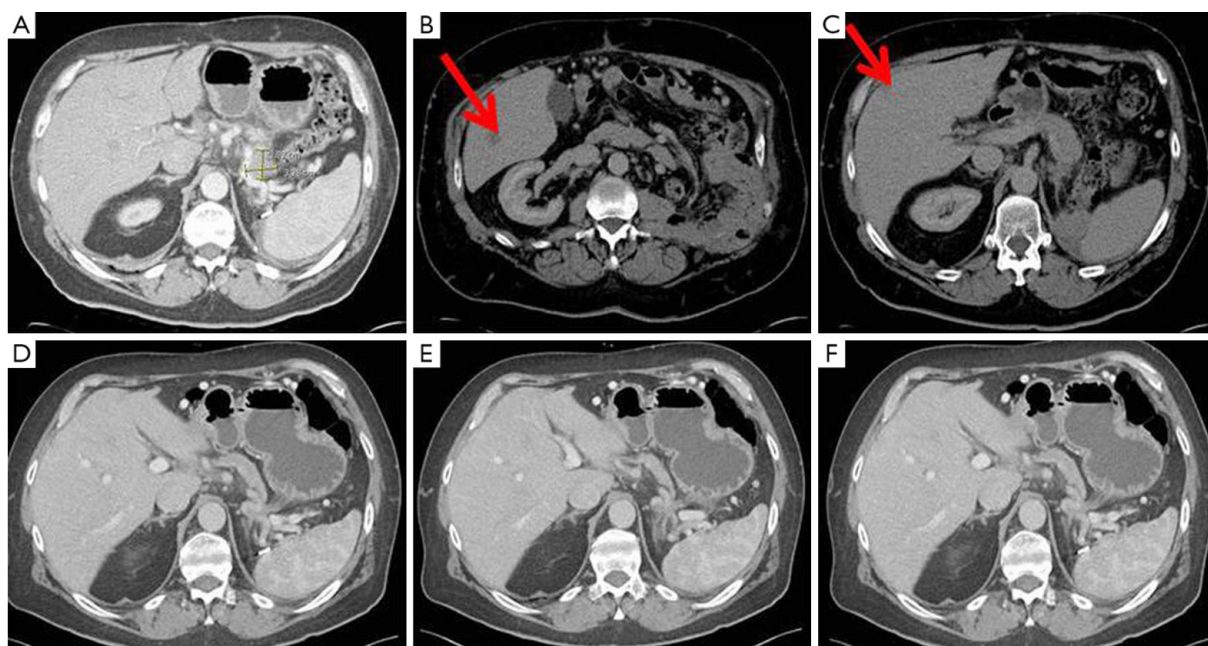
Sixty-six year-old man diagnosed with: biopsy-proven PDAC seen on CT (A); the patient also had synchronous biopsy-proven liver metastases (B and C, red arrows); he underwent neoadjuvant chemotherapy with 5-FU, leucovorin, oxaliplatin, and irinotecan with radiologic response 24 months after diagnosis (D-F). Surgical resection of the pancreas and liver lesions was performed as a one-stage procedure. The patient remained disease-free 30 months post-resection^[7]. PDAC: pancreatic ductal adenocarcinoma; CT: computed tomography; 5-FU: 5-fluorouracil
